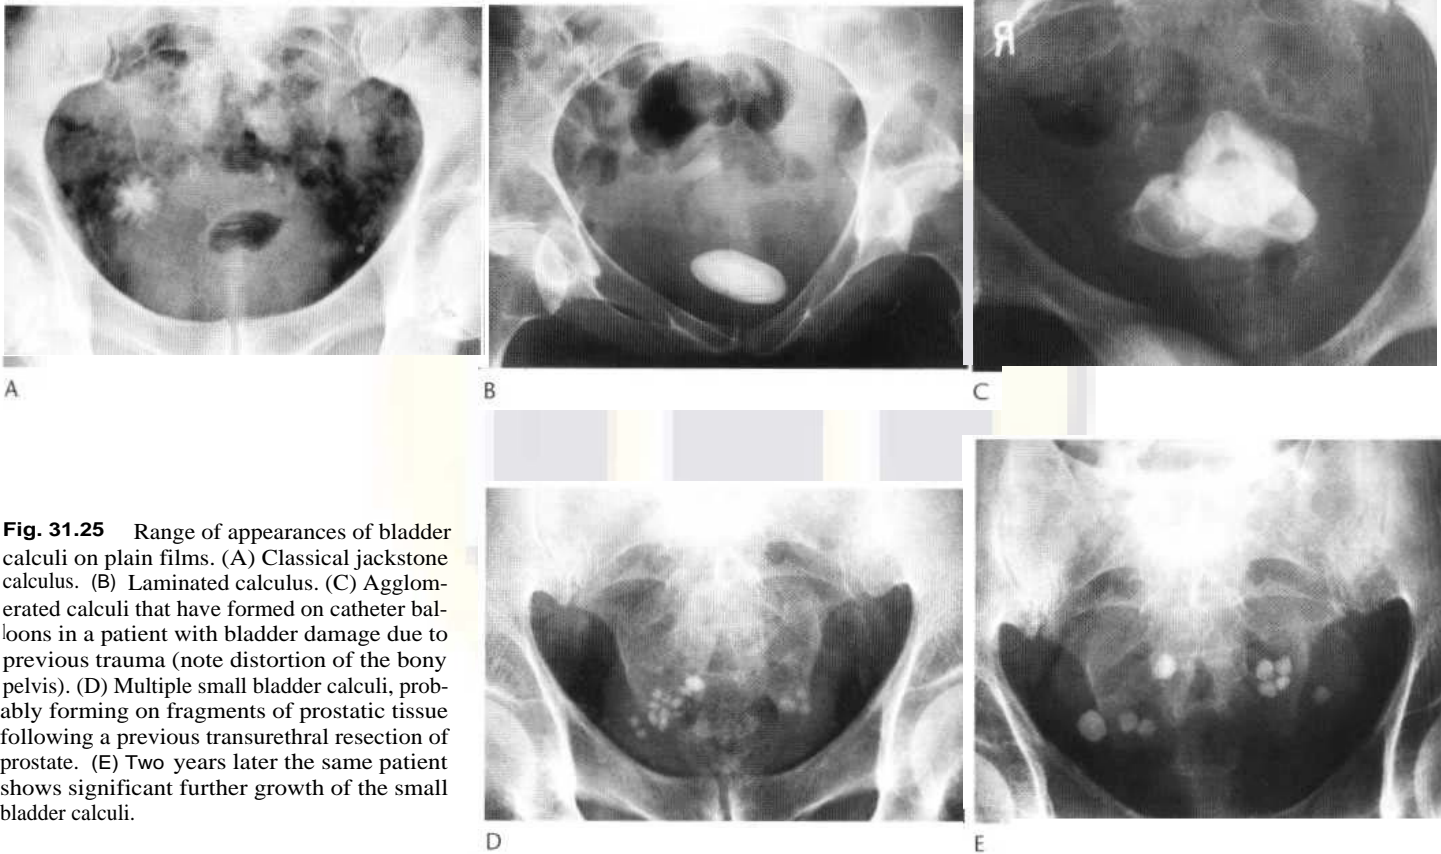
Range of appearances of bladder calculi on plain films. (A) Classical jackstone calculus. (B) Laminated calculus. (C) Agglomerated calculi that have formed on catheter balloons in a patient with bladder damage due to previous trauma (note distortion of the bony pelvis). (D) Multiple small bladder calculi, probably forming on fragments of prostatic tissue following a previous transurethral resection of prostate. (E) Two years later the same patient shows significant further growth of the small bladder calculi.
